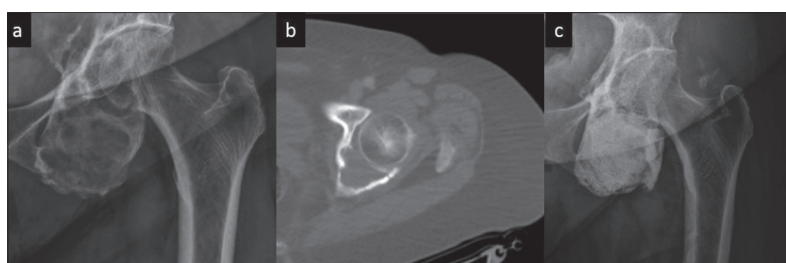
Case 4: a 64-year-old female with solitary plasmacytoma; a – preoperative X-ray; b – computed tomography view demonstrates an expansive lytic lesion extending from the posteroinferior part of the left acetabulum to inferior ramus pubis; c – five-year follow-up radiograph after curative resection and bioceramic antibacterial grafting shows graft consolidation
